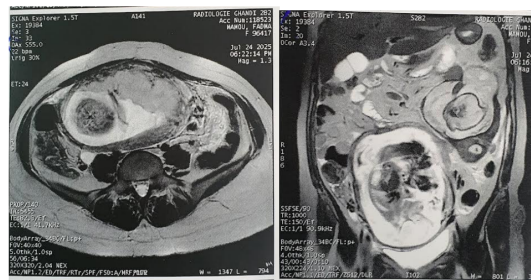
Abdominal MRI showed a uterine malformation with a triplet gestation in the larger horn and two in a rudimentary left horn, likely arrested, with a high risk of rupture.
